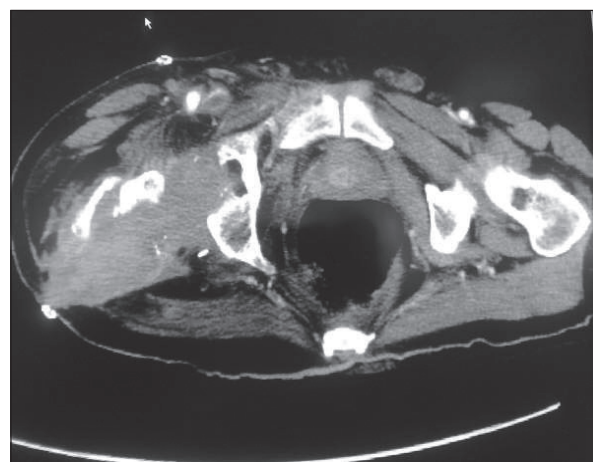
CTA. Right hip hematoma.
